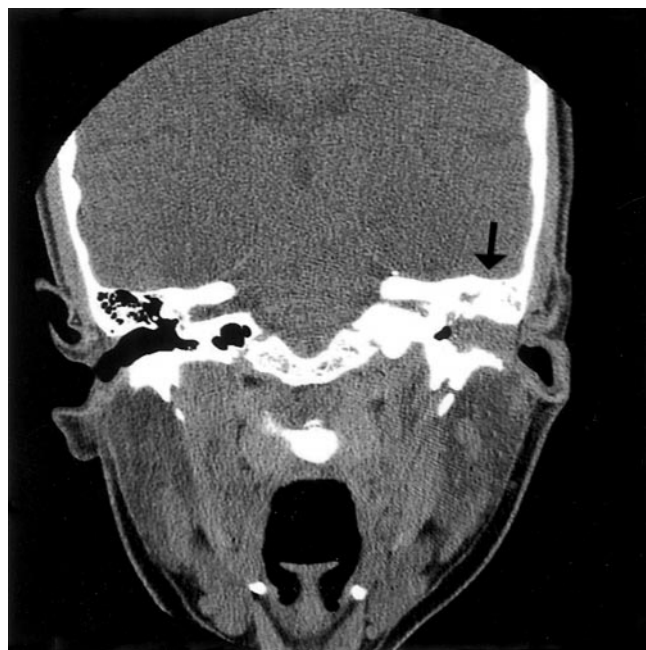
Coronal computed tomographic scan that shows a soft tissue mass (arrow) that expands at the bony margins of the left external auditory canal.
